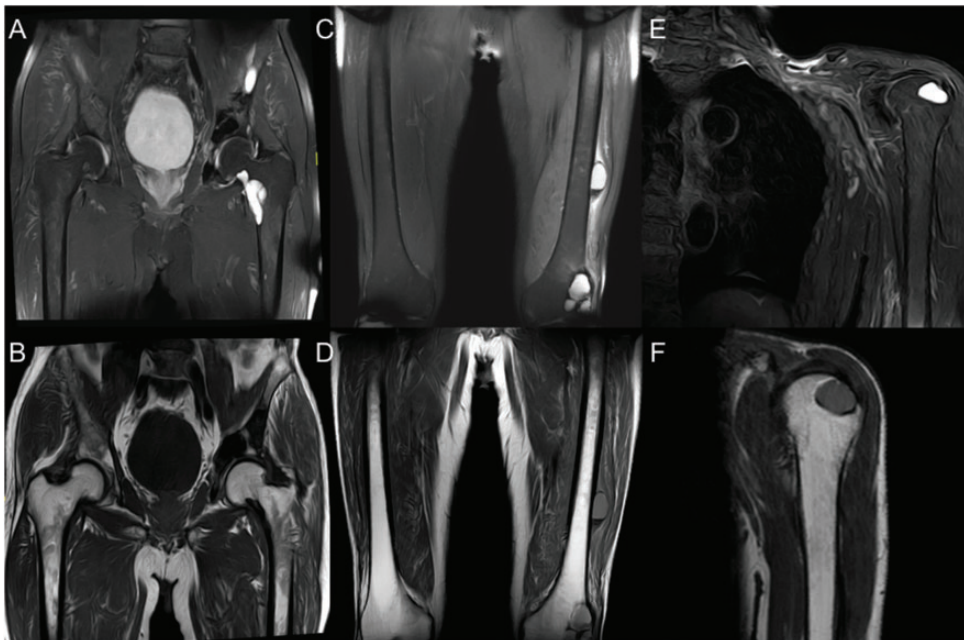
Magnetic resonance imaging of bilateral hips, bilateral femurs, and the left shoulder joint. Coronal T2 weighted image with fat suppression (a), coronal T1 weighted image (b) of bilateral hips. Coronal T2 weighted image with fat suppression (c), coronal T1 weighted image (d) of bilateral femurs. Coronal T2 weighted image with fat suppression (e), sagittal T1 weighted image and (f) of the left shoulder joint.
